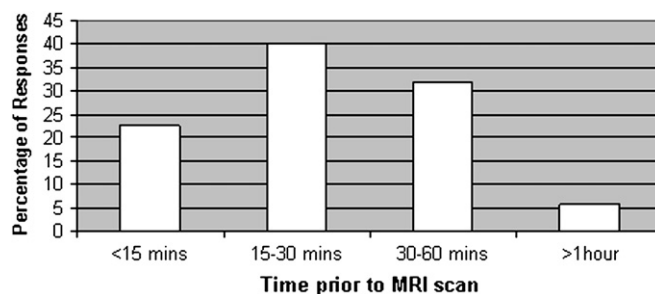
Length of time between administration of anxiolytic drug and commencement of MRI scan.
